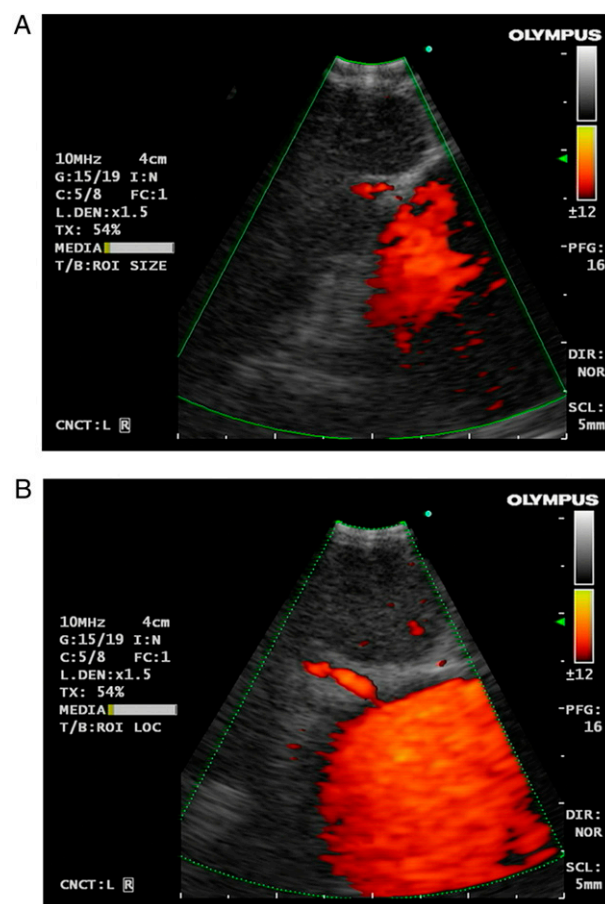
Image of an enlarged lymph node in the position 4l with the endobronchial ultrasound (EBUS) scope from the endobronchial view (A) and the endoesophageal view (B). Orange areas show Doppler flow in a vessel.
